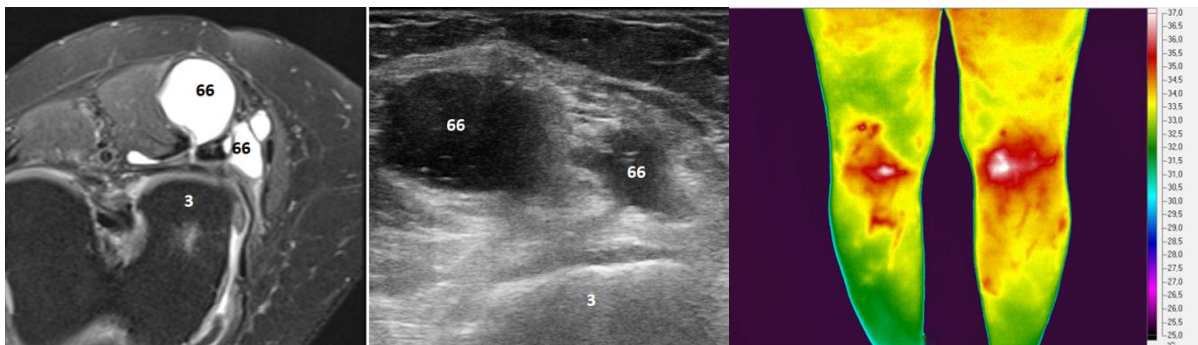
sono, Fig.8b.MRI, Fig.8c.TMV. Sono, MRI: two deeper seated bursae in the medial part of fossa poplitea on the left. TMV: hypothermia on the left in PA projection. 3. condylus medialis tibiae posteriorly, 66. bursa.
